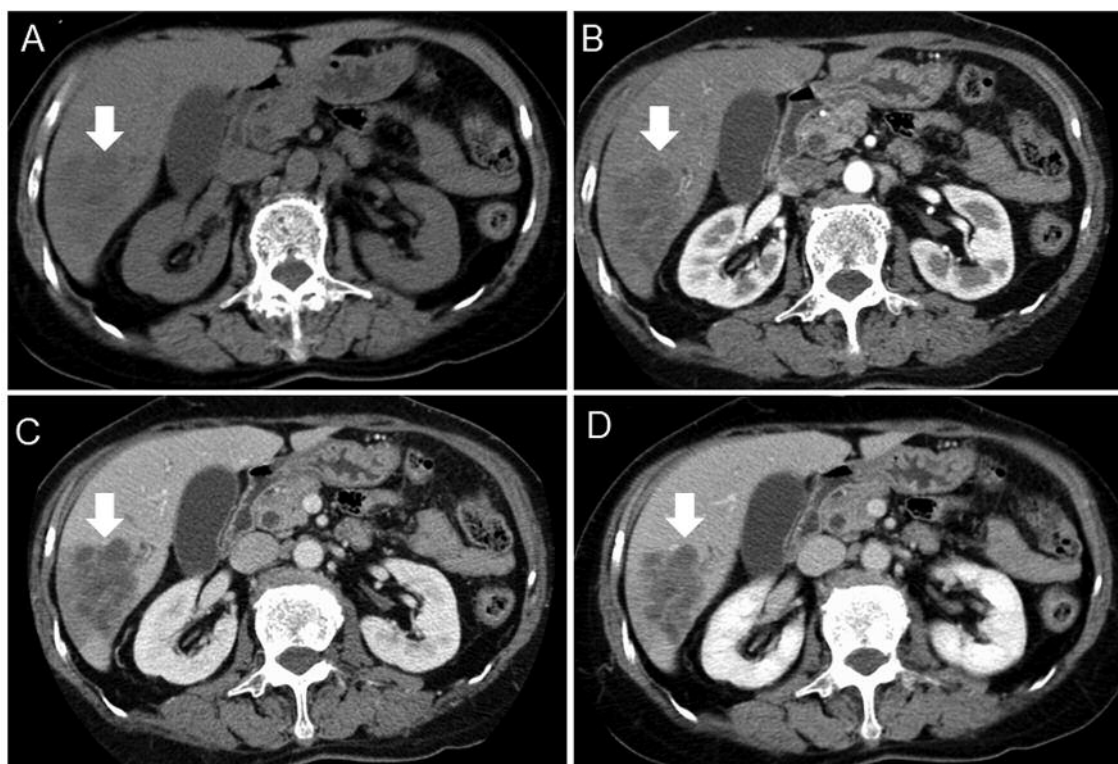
Plain computed tomographic (CT) findings (A) and arterial-phase (B), portal-phase (C) and venous-phase (D) contrast-enhanced CT findings before first hepatectomy. CT showed a multinodular low-density lesion, 6 cm in diameter, in the posterior sector of liver. The lesion was partially enhanced without washout.
